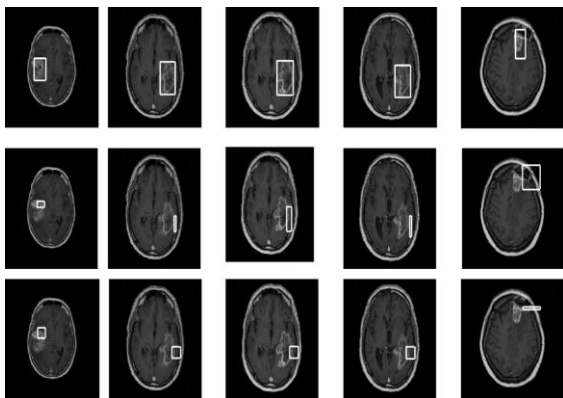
T1C axial brain MRI slices: top row, results of the FBB technique; middle row, results of intensity based bounding box algorithm (IBB); bottom row, results of entropy based bounding box algorithm (EBB).
